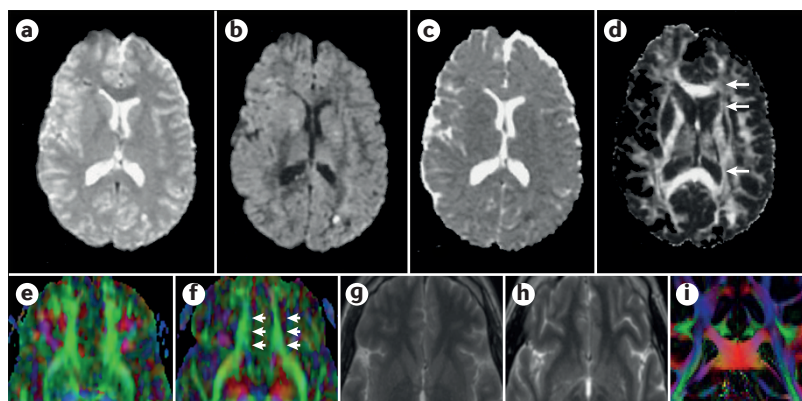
Diffusion tensor imaging for assessment of diffuse axonal injury. Diffusion tensor imaging (DTI) MRI maps macroscopic axonal organization by measuring the diffusion of water molecules in the brain. Unlike conventional MRI sequences (T2-weighted, diffusion-weighted and trace diffusion) (parts a–c), DTI reveals a reduction in diffusion anisotropy (arrows; part d) and, therefore, evidence of axonal injury after concussive or mild traumatic brain injury (TBI). In a member of the US Military who experienced blast-related concussive TBI, DTI reveals neuronal abnormalities through a reduction in relative anisotropy (part e), indicated by a less-bright green colour (arrows; part f) that were not detected with conventional T2-weighted MRI (part g and part h). Using high spatial resolution DTI in a control without TBI, the individual white matter tracts can be distinguished from each other and from surrounding structures more clearly than using lower spatial resolution DTI seen in part a and part c (part i). The colours in part i indicate the primary direction of white matter tracts detected by DTI: green indicates anterior–posterior, red indicates right–left and blue indicates rostral–caudal. Images in parts a–d are from REF. 222, republished with permission of American Society of Neuroradiology, from Diffusion tensor MR imaging in diffuse axonal injury, Arfanakisa, K. *et al.*, 23, 5, 2002. Images in parts e–h courtesy of C. L. Mac Donald, University of Washington, Seattle, Washington, USA, and D.L.B. Image in part i courtesy of L. Holleran, National University of Ireland Galway, Ireland, and D.L.B.
